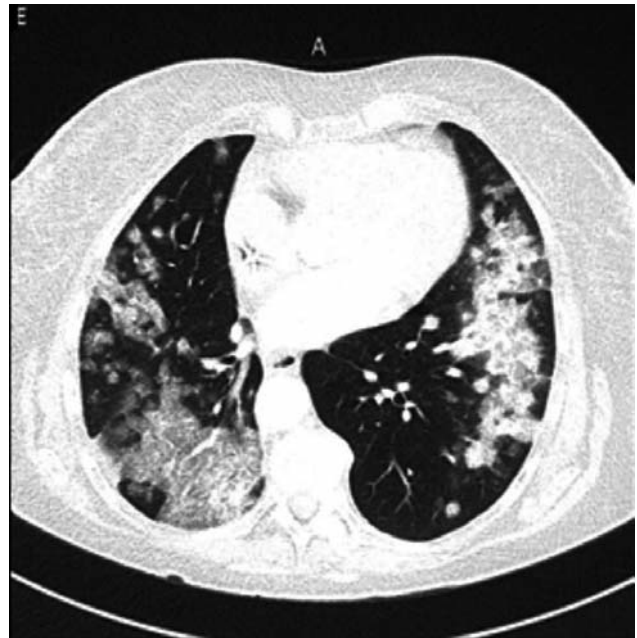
Chest CT of the first patient. Repeated CT demonstrated stable disease.
